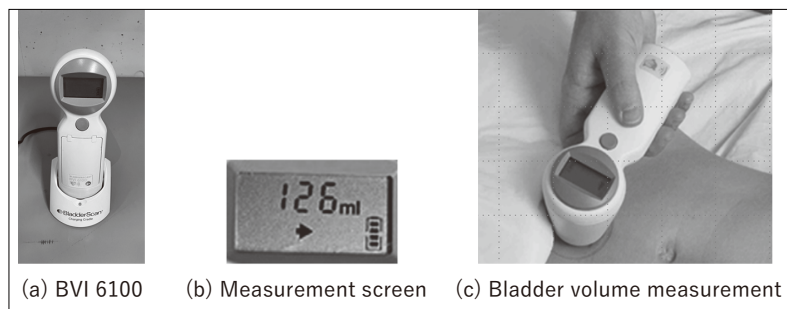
Bladder ultrasound diagnostic imaging device and bladder volume measurement
